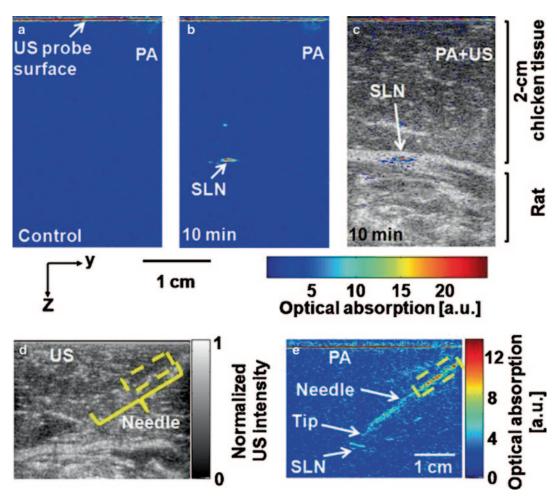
Handheld array-based photoacoustic probe for guiding needle biopsy of SLN In vivo photoacoustic (*PA*) and ultrasound (*US*) B-scan imaging of an sentinel lymph node (*SLN*) dyed with indocyanine green (ICG) and guiding of a biopsy needle: a control PA image acquired before ICG injection, b PA image taken 10 min after ICG
